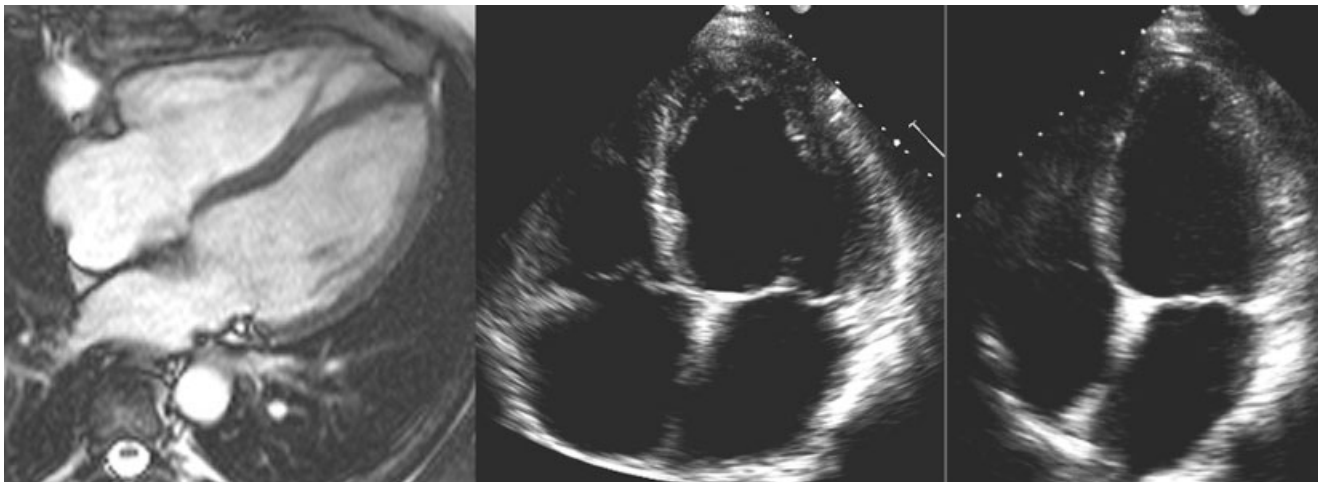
In these panels, we show, to the left, the transvalvar four chamber view as obtained using magnetic resonance imaging, in the middle the echocardiographic transvalvar four chamber view, and to the right, the echocardiographic segmental four chamber view.
